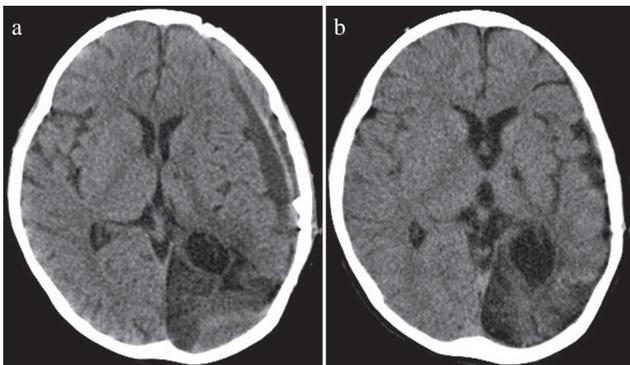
Head CT on 1-month post-embolization demonstrates regression of the left subdural hematoma (SDH) (a). The SDH continued to regress until complete resolution is seen on 9-month post-embolization CT (b).
